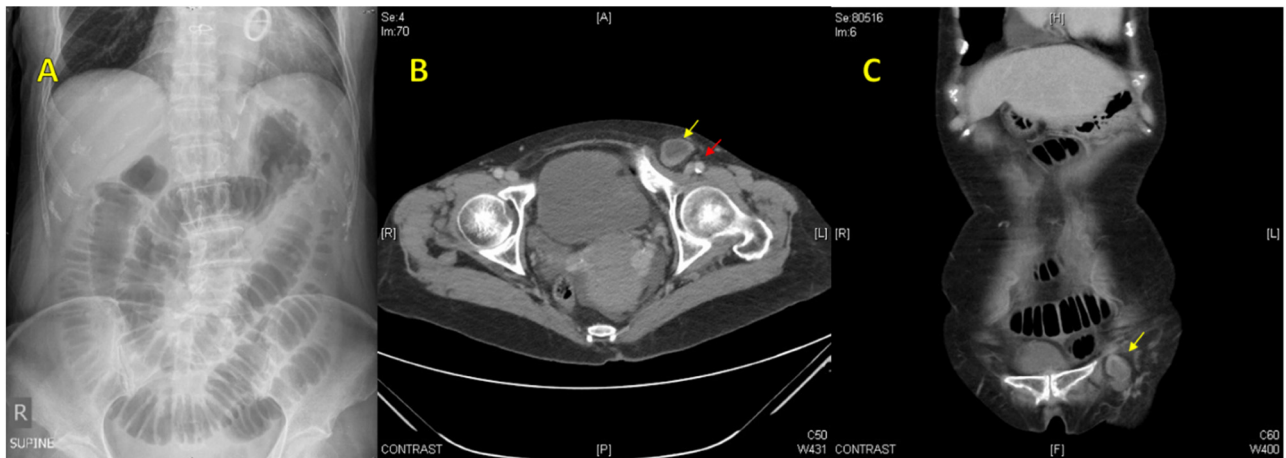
A- Abdominal radiograph showing small bowel obstruction. B,C- Axial and coronal computed tomography images showing an incarcerated femoral hernia (yellow arrow) and adjacent femoral vessels (red arrow).
